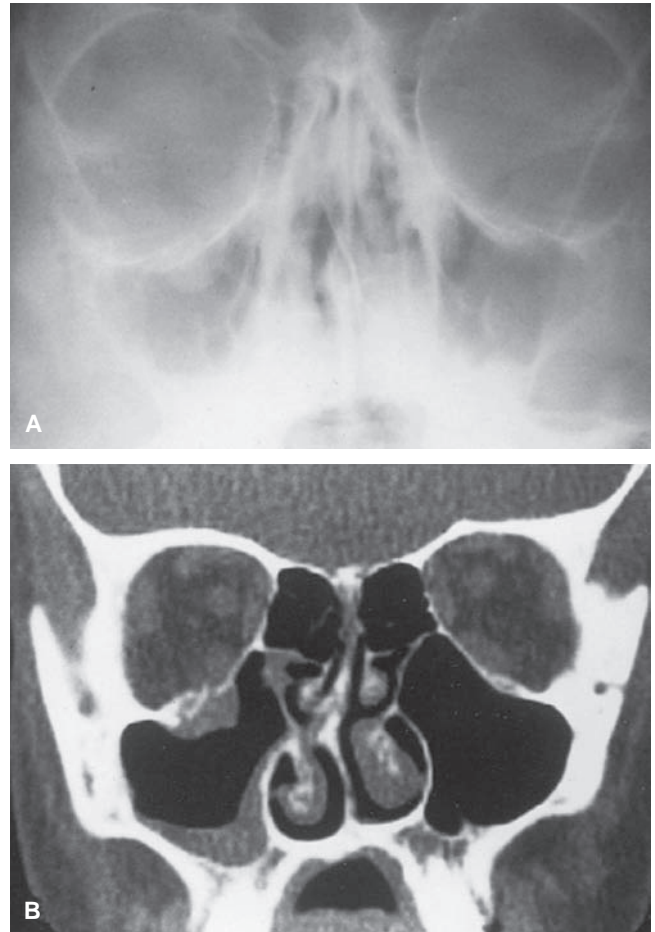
A: Blowout fracture. The sinus view shows teardrop configuration of the blowout fractures in the right orbit. Note associated fracture through the orbital floor and air–fluid level in the maxillary sinus. B: In the same patient as (A), computed tomography section more clearly demonstrates the multiple fragment fracture through the orbital floor. Teardrop and air–fluid level are evident in the right maxillary sinus. (Courtesy of Soroosh Mahboubi, MD.)
